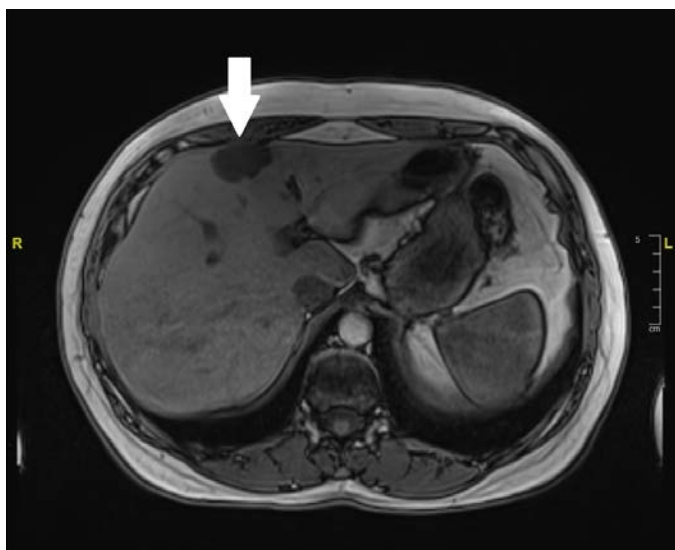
Axial MRI scan image of the abdomen showing the left hepatic lobe simple cyst (marked by arrow).
